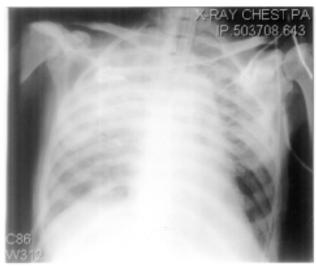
Chest roentgenogram showing bilateral alveolar opacities consistent with ARDS.
